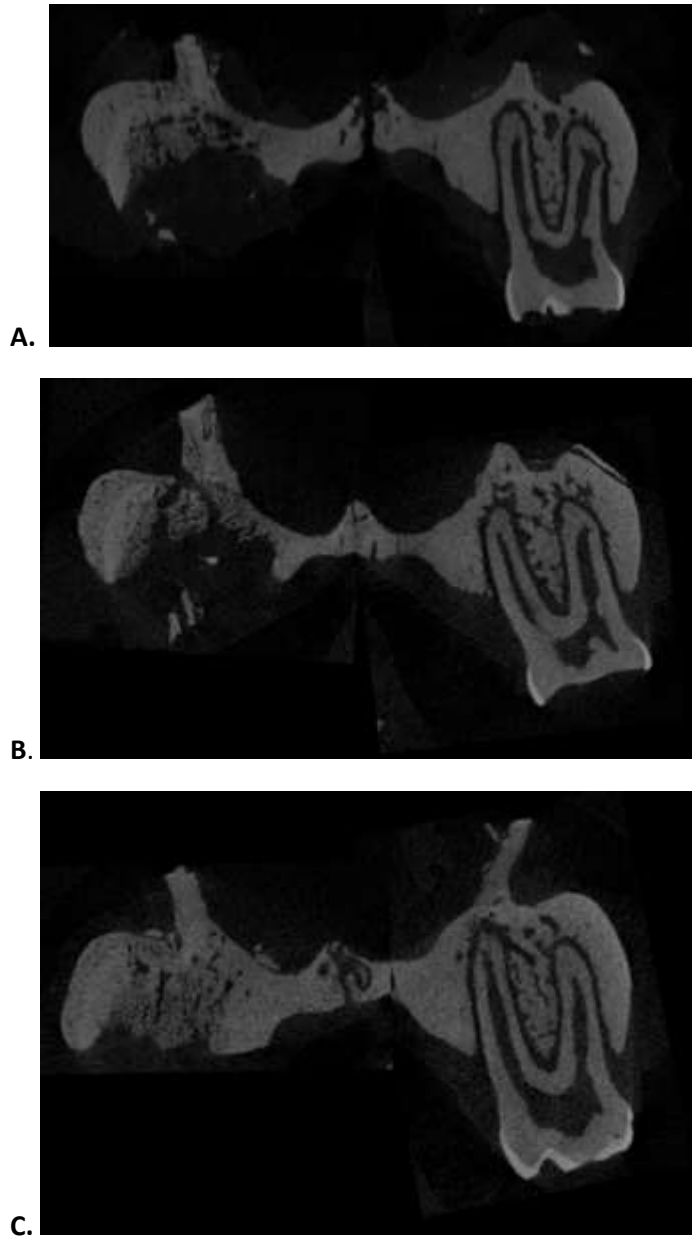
Representative μ CT for buccal and palatal bone changes from Part 2.
